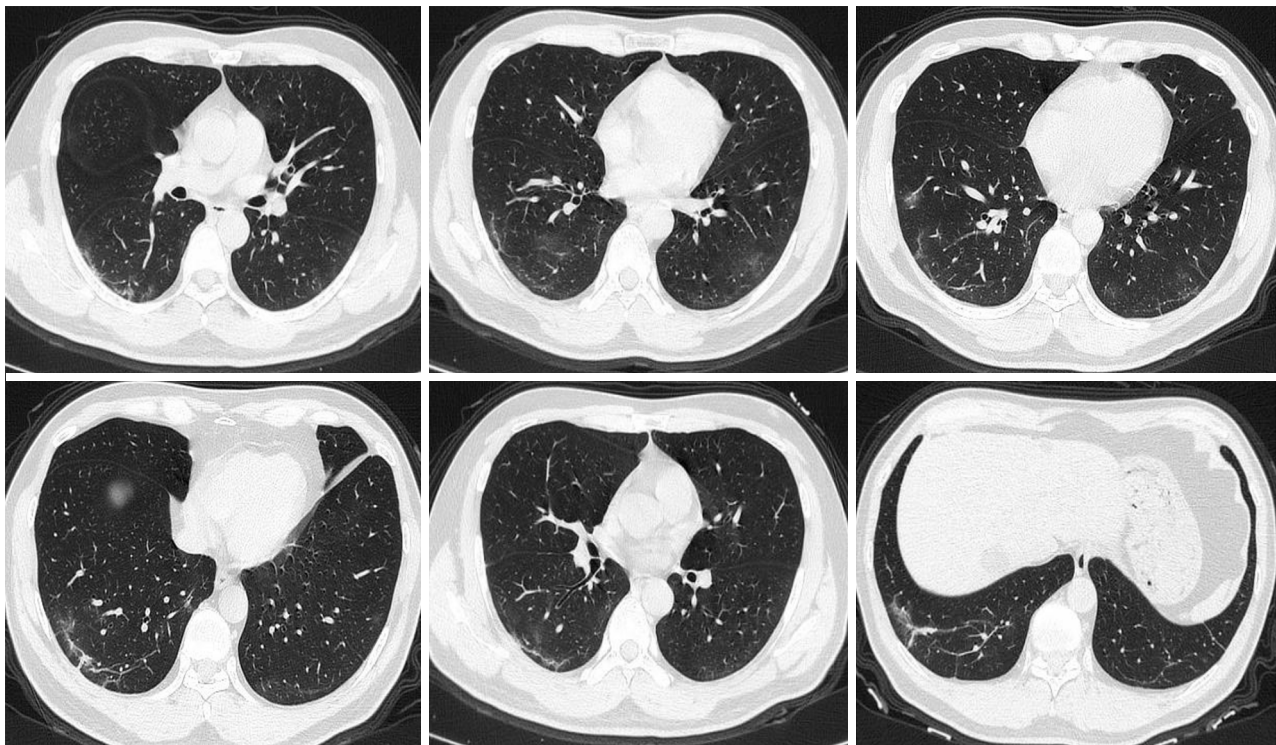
Case 2, a 49 years old male, CT shows patchy ground-glass opacity in the lower lobes of both lungs, with unclear boundary and multiple linear shadows.
